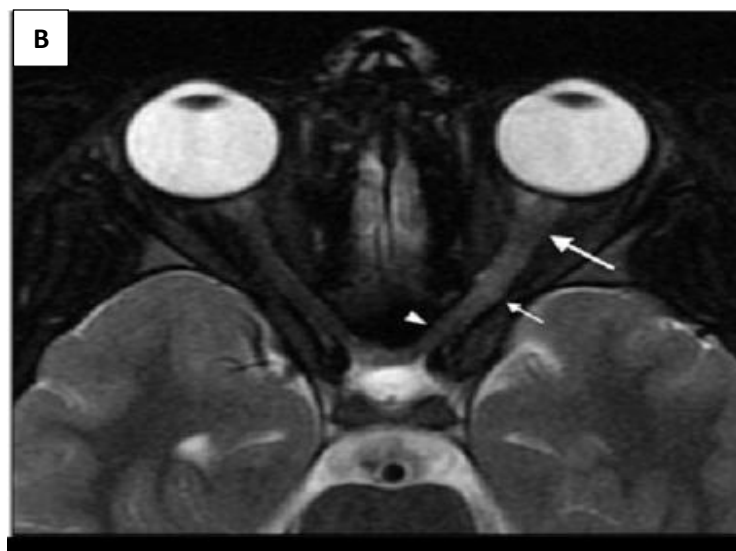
B showing T2 Magnetic resonance imaging of orbit axial section showing intrasubstance T₂ flair hyper intense signal in left optic nerve
